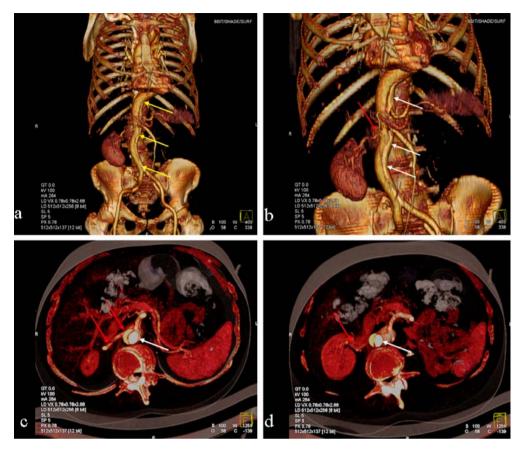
CEUS sagittal plane, demonstrating perfusion of true (*yellow arrow*) and false (*red arrow*) lumen (a, b). Early contrast enhancement of true lumen after 27 s (a) Fig. 9 Same patient as Figs. 6, 7 and 8. CTA in 3D reconstructions (a, b) showing a long aortic dissection (*yellow arrows*). CTA in axial plane (c, d) showing the right renal artery perfused from the false lumen (*red arrows*) and the true (*white arrows*) and false lumen of the aorta
